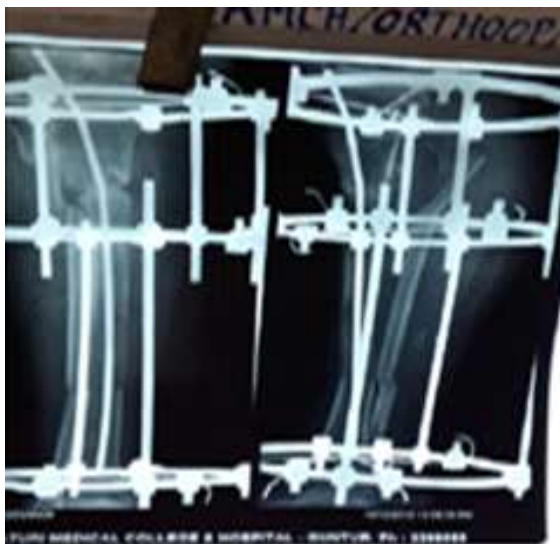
Post-operative radiograph after sequestrectomy and distal corticotomy with ilizarov fixator
